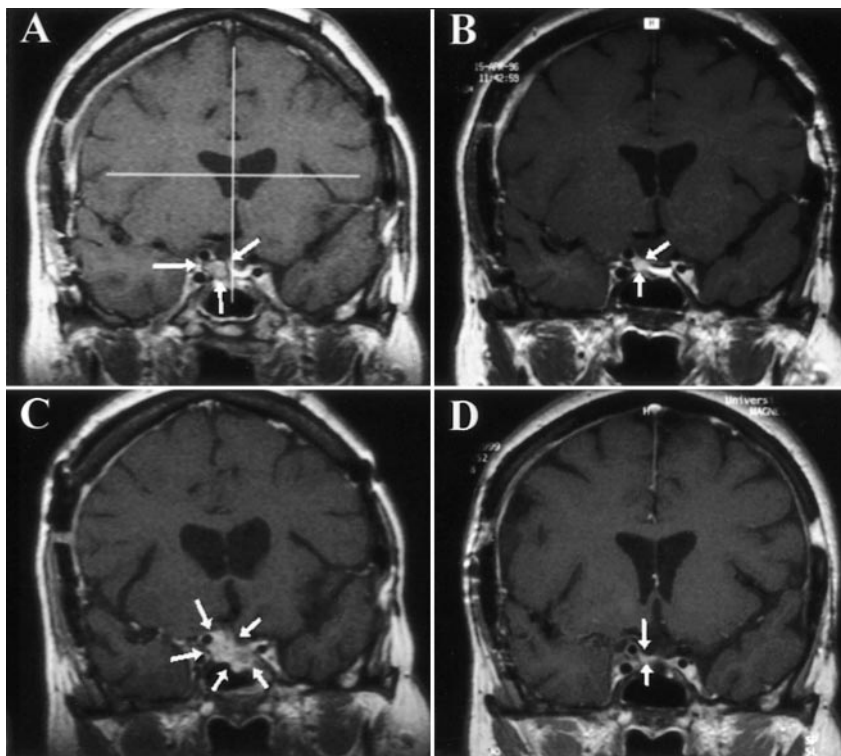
A 47 year old woman with a right cavernous sinus hemangiopericytoma as shown on the treatment post contrast coronal T1 weighted MRI (A). Three months later the tumor shrank 70% (B). Thirty months after the initial Gamma surgery the tumor was larger than at the time of treatment and the procedure was repeated (C). Ten months after the second treatment the tumor again decreased 90% in volume. (Patient 4, Table 1.)
